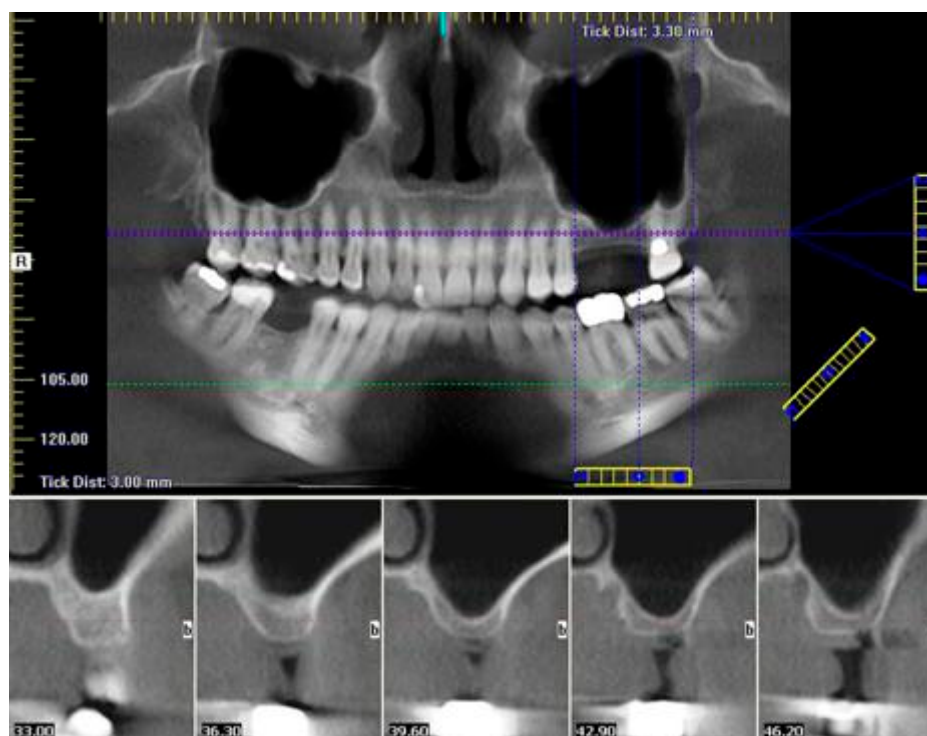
Case 1. Lateral approach. Presurgical cone-beam computed tomography of edentulous left maxillary sinus showing minimal residual bone height.
